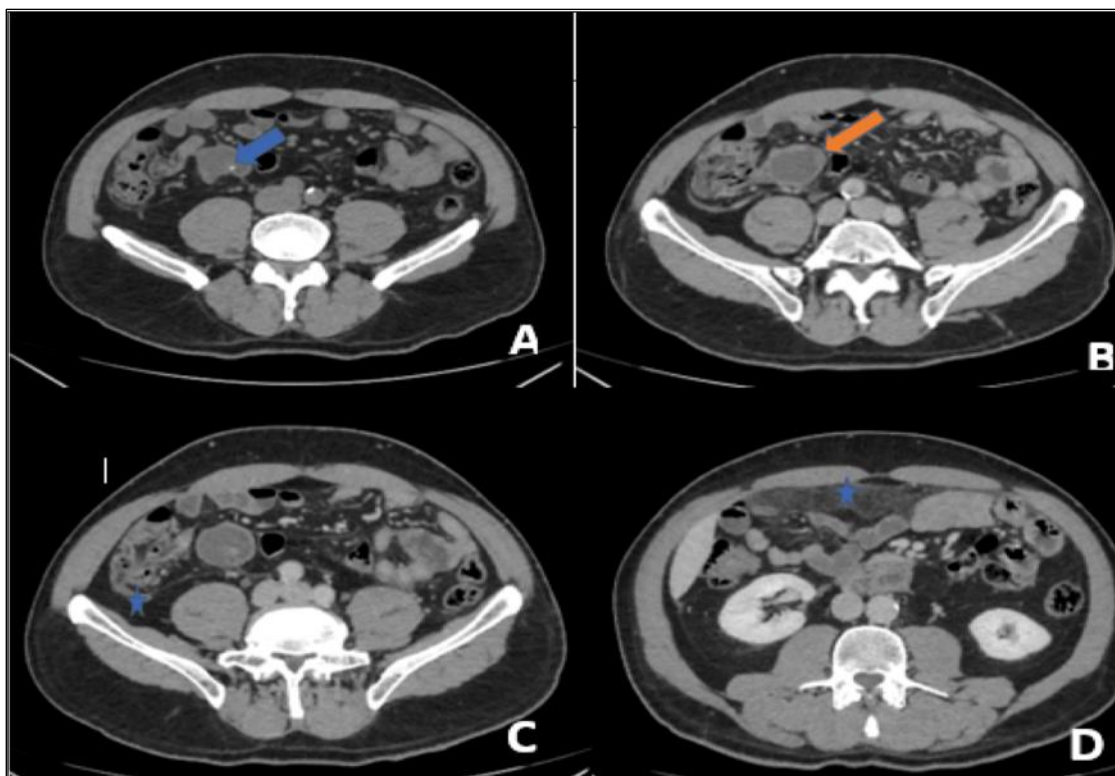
Axial pre-contrast (A) and post-contrast (B-D) CT images demonstrating a cystic appendiceal lesion containing a mural calcification (blue arrow), with an irregular thickened and enhancing wall (orange arrow), associated with infiltration of the peritoneum of the right paracolic gutter (asterisk).
